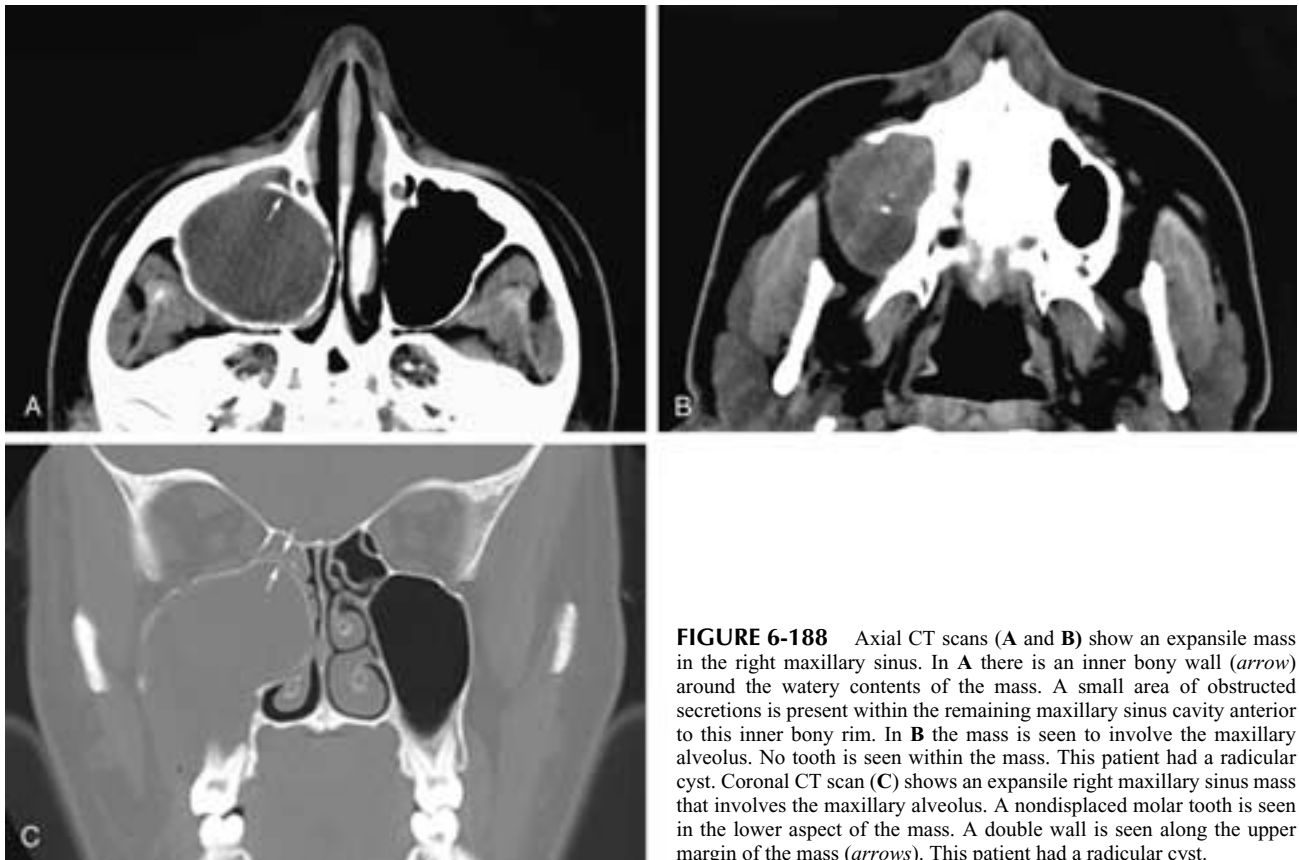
Axial CT scans (A and B) show an expansile mass in the right maxillary sinus. In A there is an inner bony wall (*arrow*) around the watery contents of the mass. A small area of obstructed secretions is present within the remaining maxillary sinus cavity anterior to this inner bony rim. In B the mass is seen to involve the maxillary alveolus. No tooth is seen within the mass. This patient had a radicular cyst. Coronal CT scan (C) shows an expansile right maxillary sinus mass that involves the maxillary alveolus. A nondisplaced molar tooth is seen in the lower aspect of the mass. A double wall is seen along the upper margin of the mass (*arrows*). This patient had a radicular cyst.
